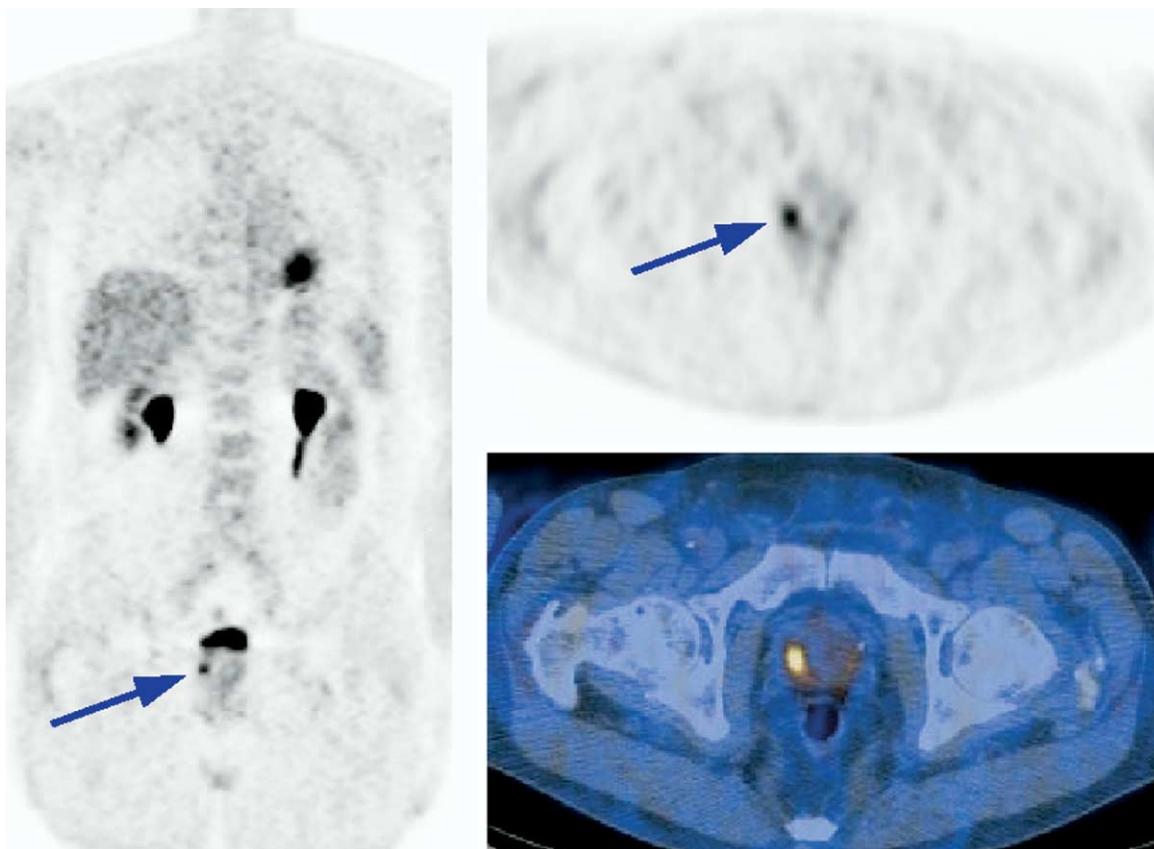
Incidental focal FDG uptake in the prostate gland of an 80-year-old patient with T-cell lymphoma using PET for staging of his disease. Coronal and transaxial PET images show focal FDG uptake beneath the urinary bladder (arrow), which on PET-CT fusion image localizes to the prostate. PSA was 87 ng/mL. (Color version of figure is available online.)
